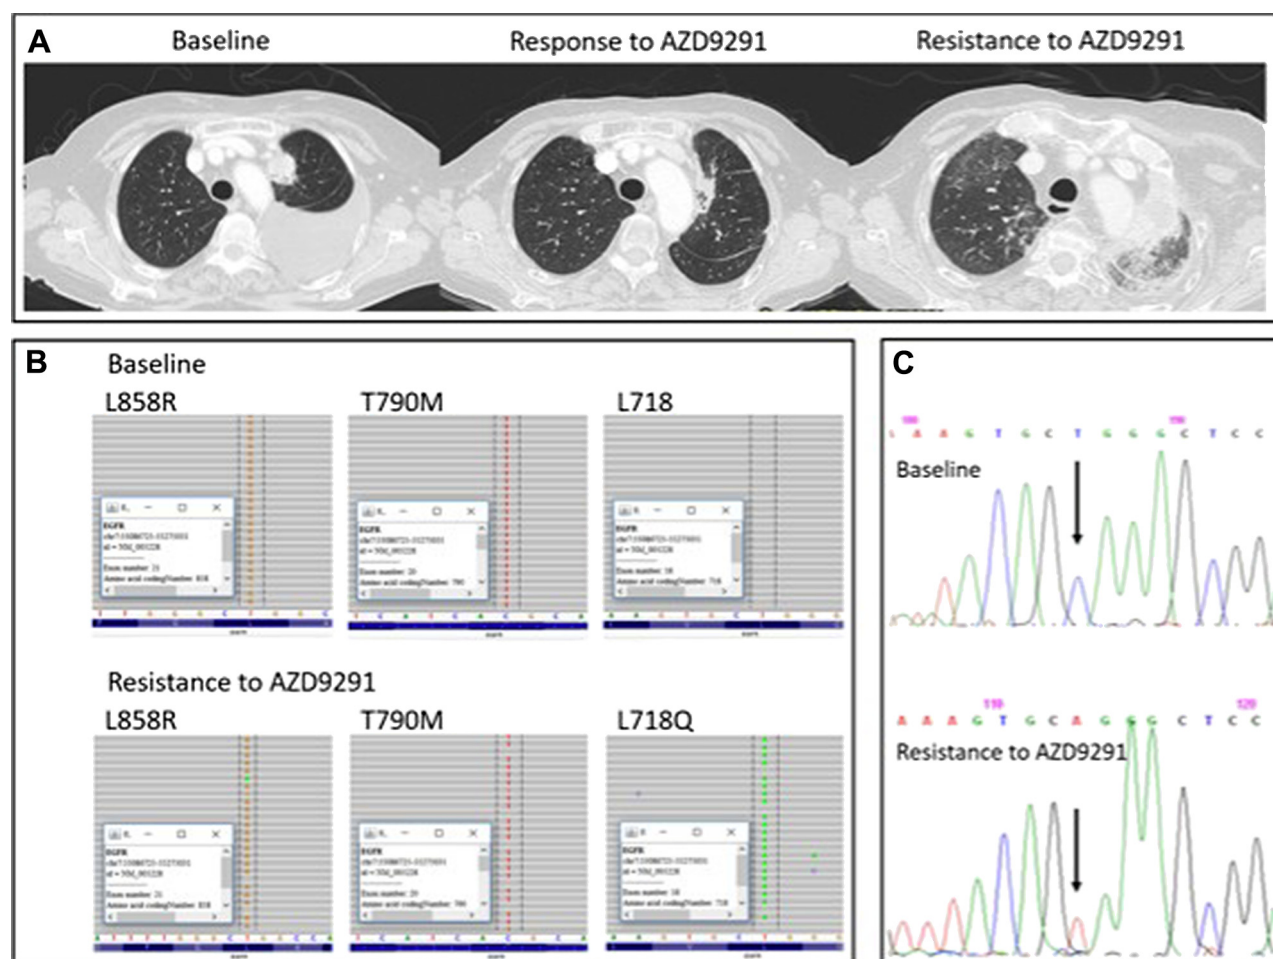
Acquired resistance to AZD9291. (A) Computed tomography of the chest showed the tumor at baseline before AZD9291 treatment (left), a partial response (middle), and progressive disease after treatment with AZD9291 (right). (B) The Integrative Genomics Viewer (Broad Institute, Cambridge, MA) revealed the mutational status of tumor at baseline (top) and after AZD9291 therapy (bottom). Next-generation sequencing was performed with TruSight Tumor 26 genes (Illumina, San Diego, CA) on the MiSeq platform (Illumina). (C) Sanger sequencing of EGFR exon 18 gene confirmed the occurrence of L718Q mutation in the tumor.
